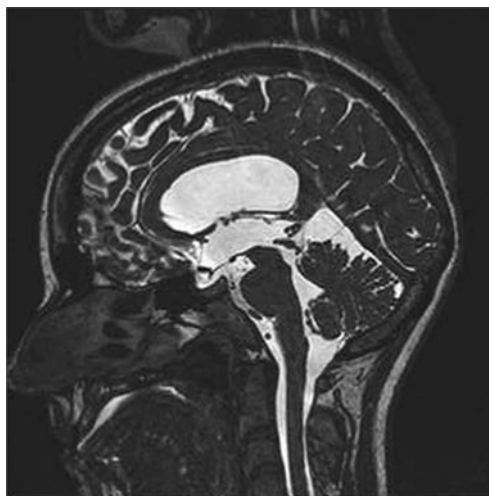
Postoperative sagittal MRI with CISS sequence showing tumour being adequately resected from the Aqueduct of Sylvius
